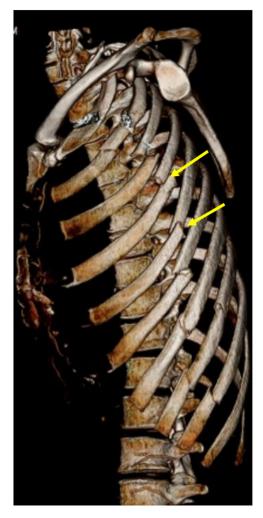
CT reconstruction of patient's rib fractures. Arrows indicate the fractures suspected to have violated the patient's implant capsule.
